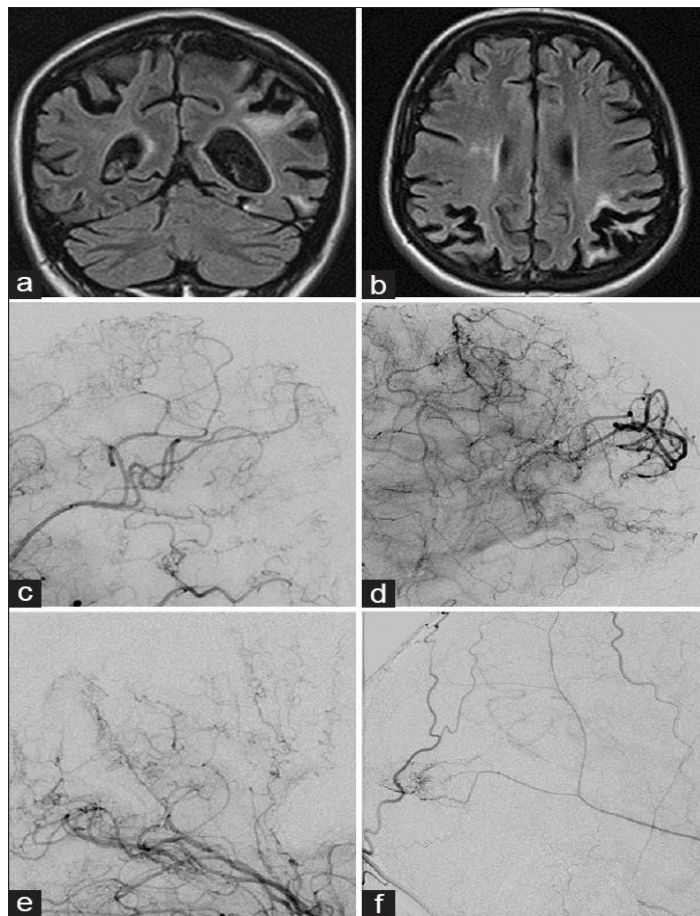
Diffuse cerebral atrophy and numerous chronic ischemic lesions in the subcortical white matter are visible on brain MRI images (a and b). The distal intracranial branches (c), areas of slow flow (d), thin and flattened distal branches (e), and transdural anastomosis are all visible on cerebral angiograms (c–f) ,(f)<sup>9</sup>.
